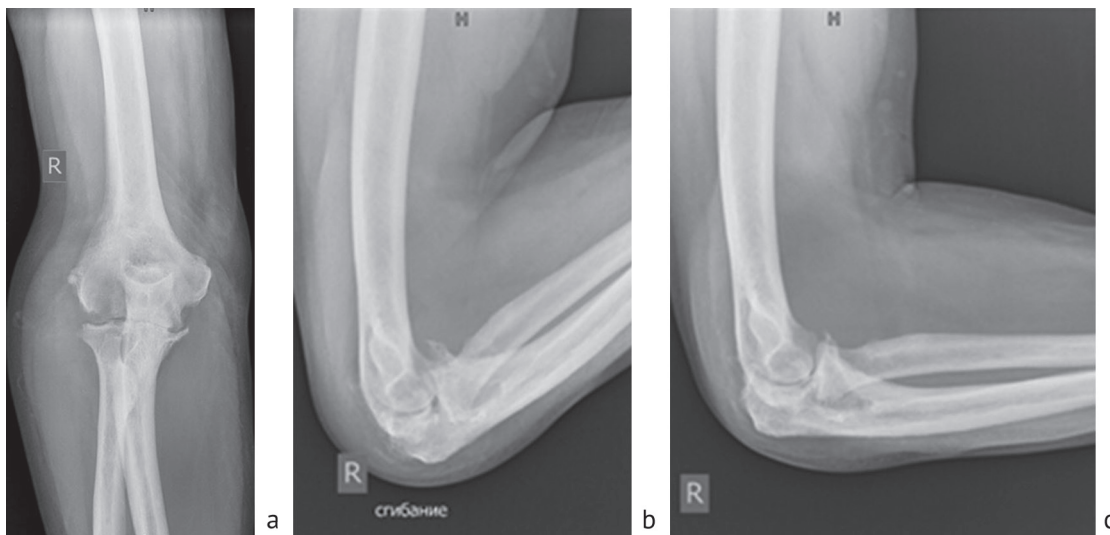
Photo from radiographs of the patient's right elbow joint in direct (a) and lateral views with maximum flexion (b), lateral view with maximum possible extension (c) of the forearm before treatment
